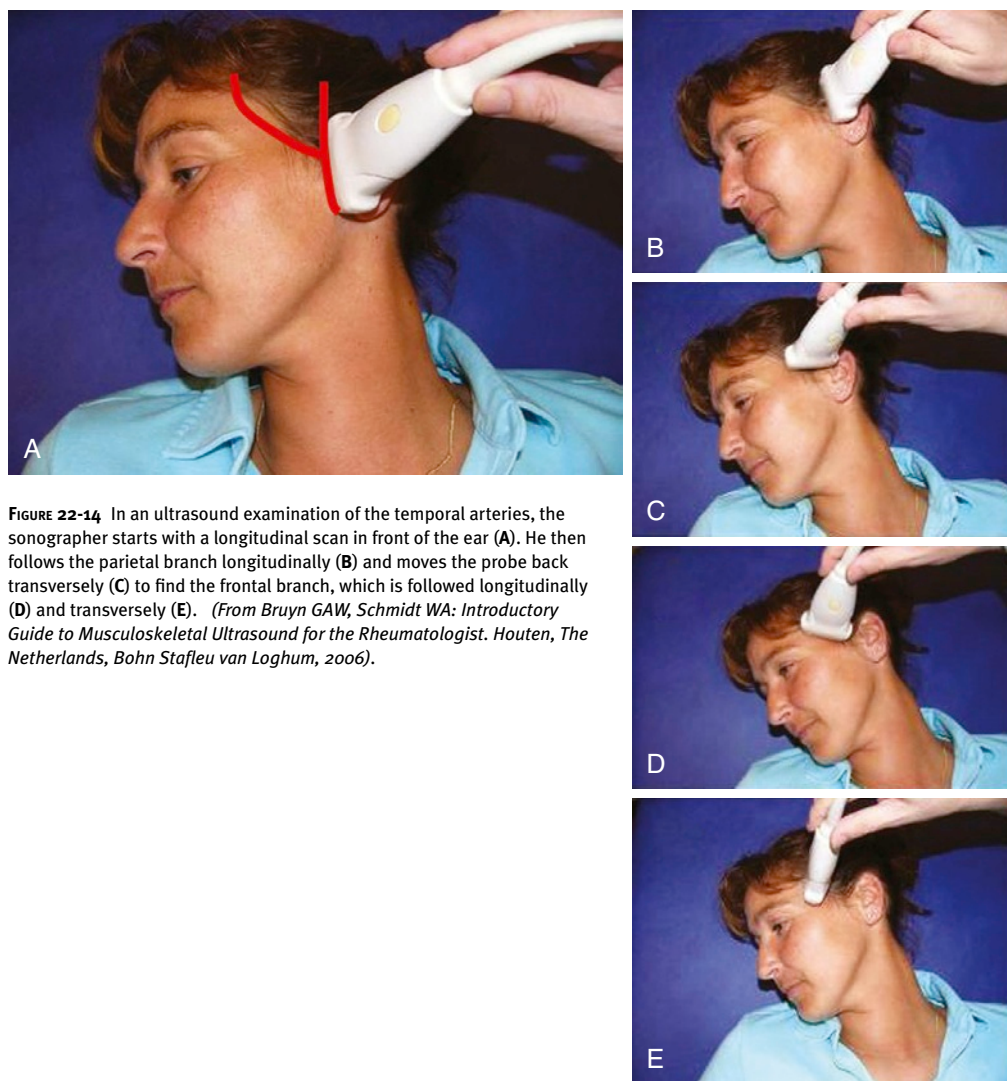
In an ultrasound examination of the temporal arteries, the sonographer starts with a longitudinal scan in front of the ear (A). He then follows the parietal branch longitudinally (B) and moves the probe back transversely (C) to find the frontal branch, which is followed longitudinally (D) and transversely (E). (From Bruyn GAW, Schmidt WA: *Introductory Guide to Musculoskeletal Ultrasound for the Rheumatologist*. Houten, The Netherlands, Bohn Stafleu van Loghum, 2006).
